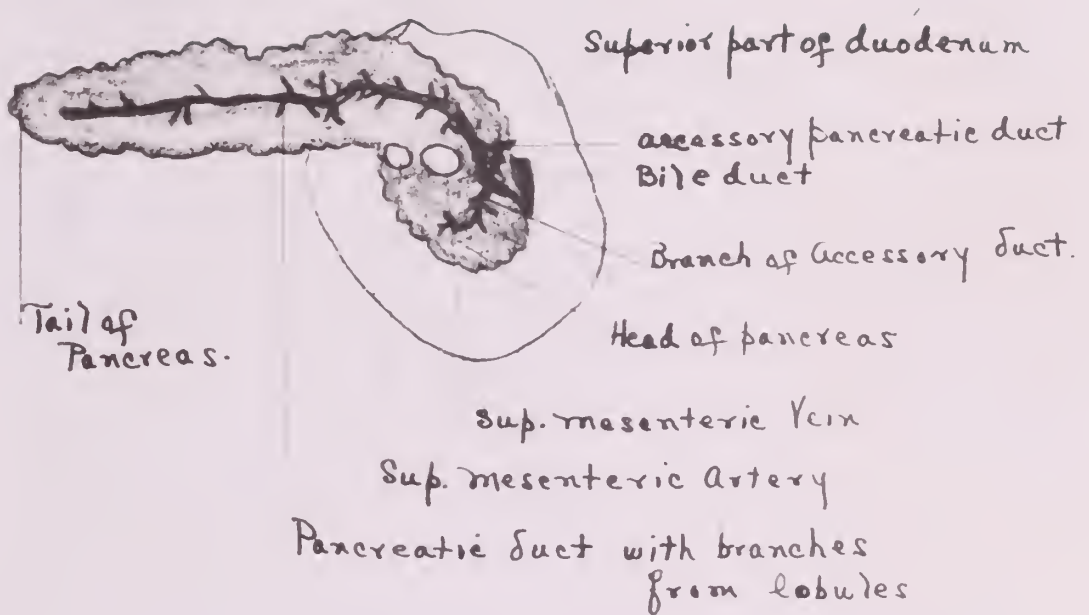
POSTERIOR ASPECT OF THE PANCREAS SHOWING DUCTS
